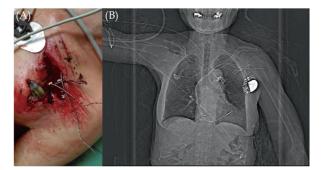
Incisional wound created by the patient with exposed pacemaker generator (A) and computed tomography showed pacemaker lead disconnection but no sign of dislodgement (B).
